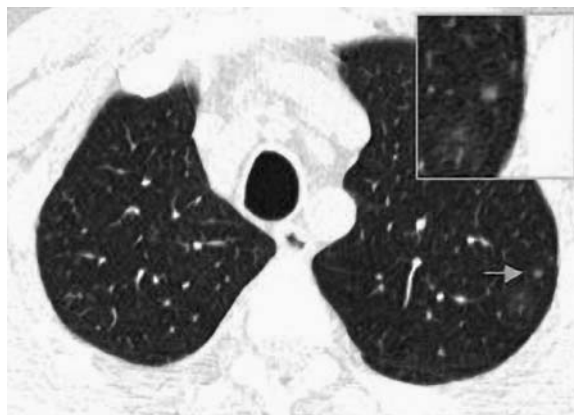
2 mm CT image demonstrating characteristic small centrilobular ground-glass opacity (GGO) with ill-defined margins. Opacity was not visible on 5 mm image
